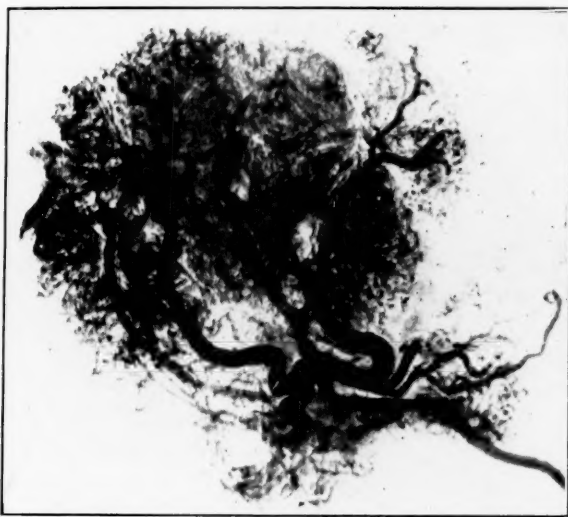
X-ray photograph of barium-gelatin injection of a full-term placenta removed during eclampsia. Note the marked peripheral congestion in the villous vessels. This is best shown by stereoscopic examination.
